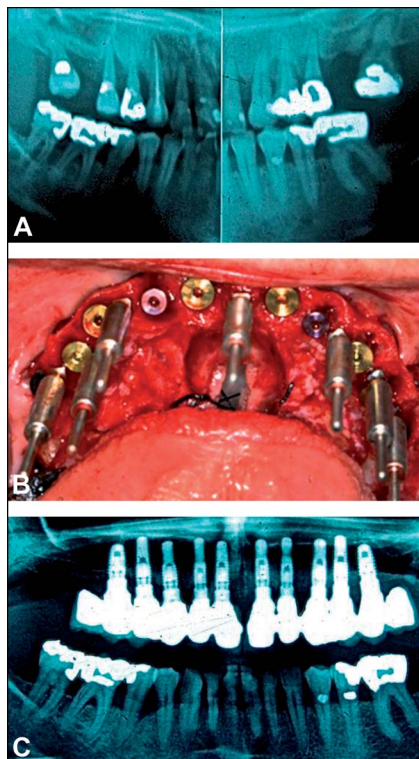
A, Preoperative radiographic image of a 47-year-old patient who presented with a hopeless maxillary dentition. B, Intraoperative view showing the placement of immediate provisional implants in the edentulous sites between the standard implants to allow for delivery of a fixed provisional restoration and allow for undisturbed healing of the implants based on conventional treatment planning principles. C, Postloading panoramic radiograph showing good bone levels around the loaded implants, at 36 months postoperatively. (Compare Figs. 1 and 2 with Figs. 3 and 4.)
